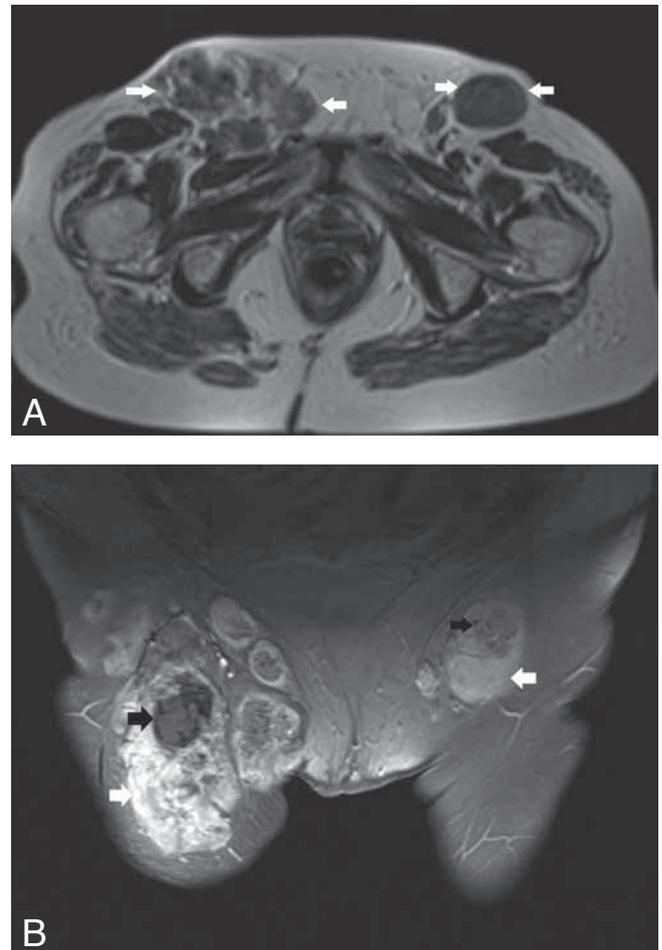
MR imaging of the groins. Axial T2-WI (A) and coronal fat-suppressed T1-WI after intravenous administration of gadolinium contrast (B). The enlarged lymph nodes are of heterogeneous signal on T2-WI, with the calcified areas being hypointense (white arrows). The noncalcified components showed vivid enhancement (white arrows), whereas the calcified solid components are nonenhancing (black arrows) (B).
